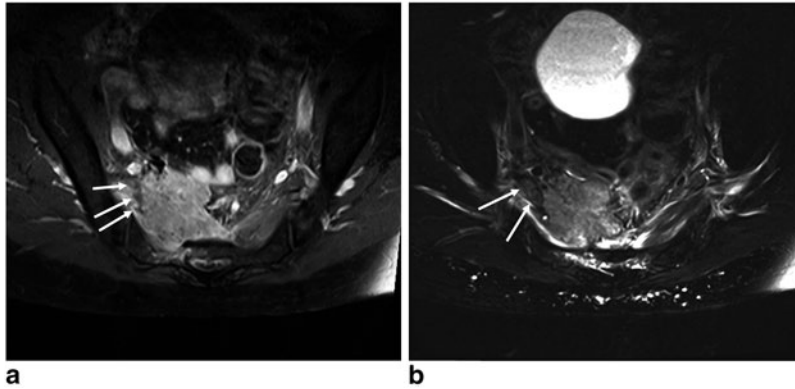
Magnetic Resonance Imaging of lumbosacral plexus. a T2-weighted images demonstrating hyperintensity along the sacral roots (S1–2). b T1 post contrast
